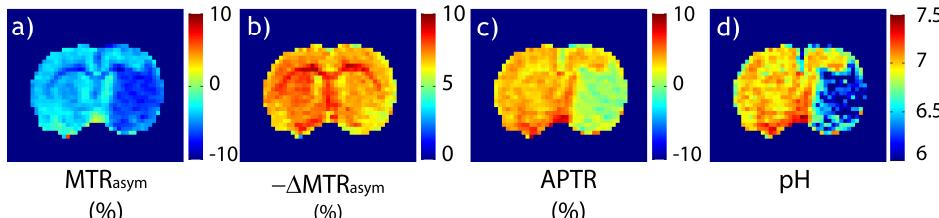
Derivation from pH-weighted MTR_{asym} (a), ΔMTR_{asym} shift (b), pH-weighted APT MRI (c) and quantitative tissue pH (d).
